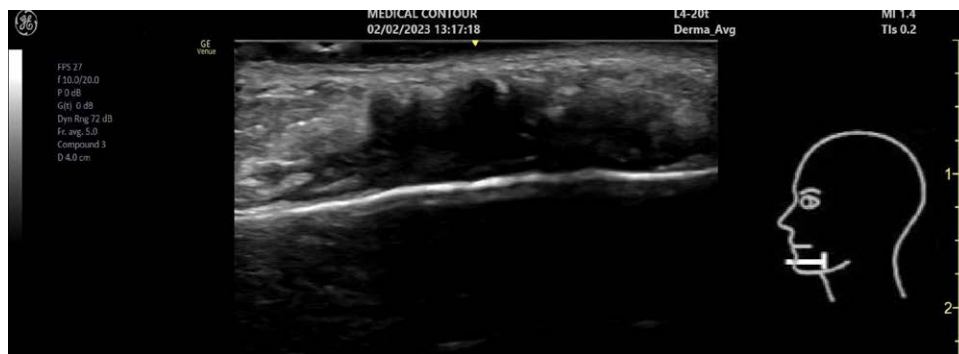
Ultrasound image (B-mode) of the reference nodule located in the prejowl-sulcus. A hypoechoic nodule of irregular shape and ill-defined border, bright hyperechoic spots with posterior mini-comet-tail artifact on the border can be observed, typical for polycaprolactone.
